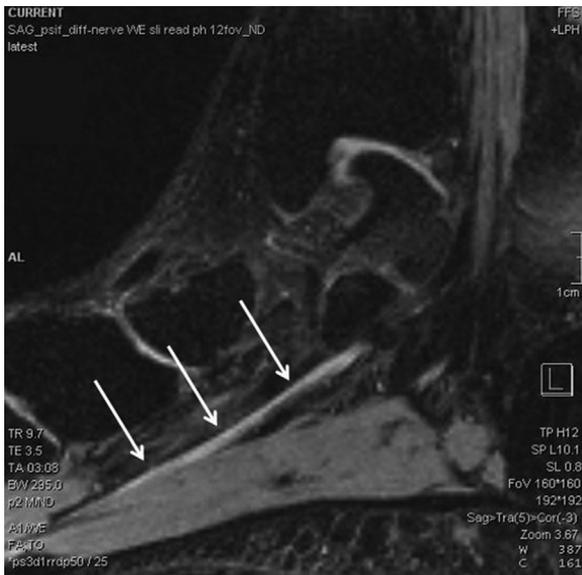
3D sagittal PSIF MR image of the medial aspect of the ankle. Note normal anatomic appearance of the medial plantar nerve (arrows) showing intermediate signal intensity.
